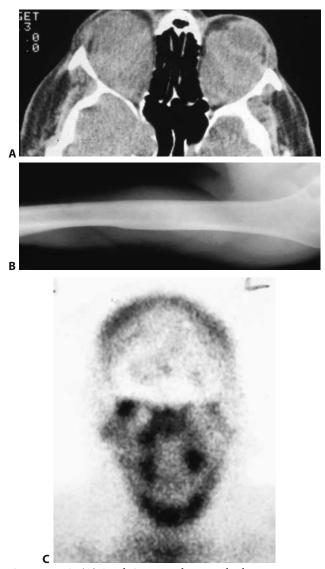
(A) Axial CT scan showing the homogeneous appearance of xanthogranuloma diffusely involving both orbits. The patient's vision was light perception in both eyes on admission. (B) X-ray of the humerus of the same patient with Erdheim–Chester disease revealing typical lytic and sclerotic changes. (C) Radionucleotide scan of the same patient with increased uptake in orbits.
